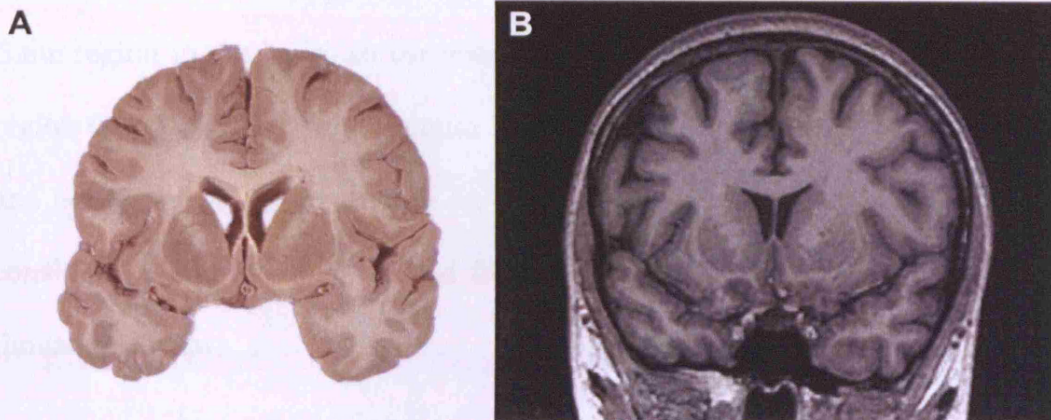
A) shows a post-mortem brain in coronal section, and B) a similar slice from a brain imaged *in vivo* using T1-weighted MRI
